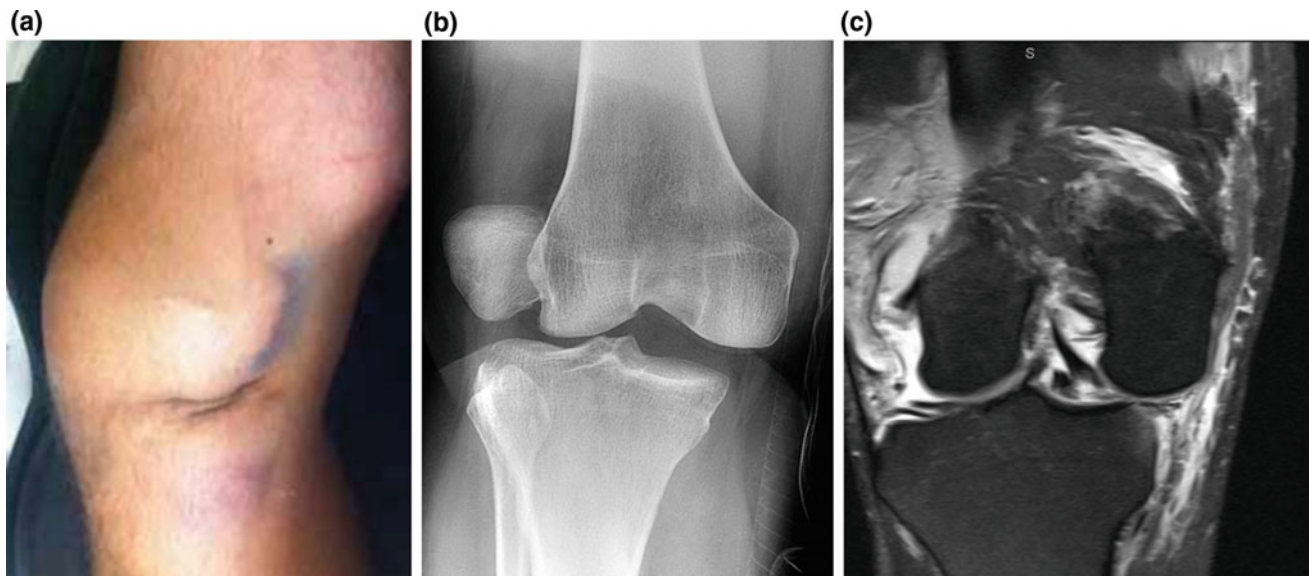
Clinical image of a posterolateral knee dislocation demonstrating classic “pucker sign” or “medial furrowing” (a). Radiograph of a posterolateral dislocation (b). This KD was irreducible and required
